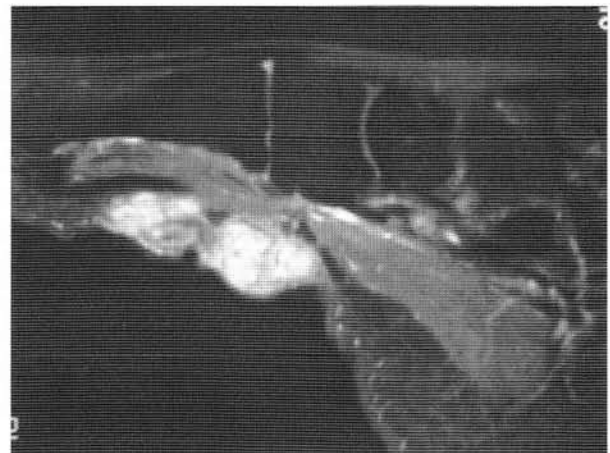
Magnetic resonance imaging of recurrent plantar fibromatosis.
